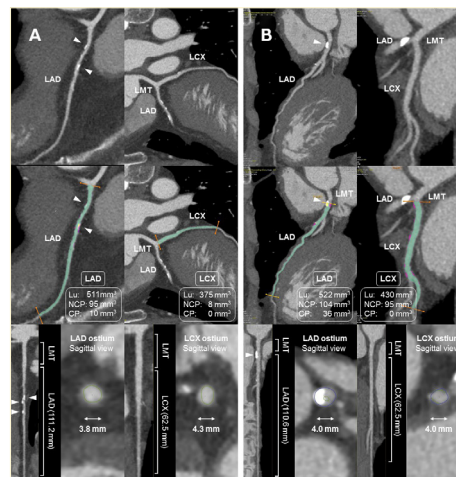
Computed tomography angiography (CTA): (A) Case 1; CTA showing no significant coronary artery stenosis in the left main trunk (LMT), left anterior descending (LAD), and left circumflex (LCX) (upper panel). Vessel components are indicated as following colors: green is lumen volume (Lu), red is non-calcified plaque volume (NCP), and yellow is calcified plaque volume (CP). The volume of Lu, NCP, and CP are 511 mm³, 95 mm³, and 10 mm³ for LAD and 375 mm³, 8 mm³, and 0 mm³ for LCX, respectively (middle panel). The vessel length coinciding with FFR_{CT} region of interest and ostium lumen diameter are 111.2 mm and 3.8 mm for LAD and 62.5 mm and 4.3 mm, respectively (lower panel). (B) Case 2; CTA showing no significant coronary artery stenosis in the LMT, LAD, and LCX (upper panel). The volume of Lu, NCP, and CP are 522 mm³, 104 mm³, and 36 mm³ for LAD and 430 mm³, 95 mm³, and 0 mm³ for LCX, respectively (middle panel). The vessel length coinciding with FFR_{CT} region of interest and ostium lumen diameter are 110.6 mm and 4.0 mm for LAD and 62.5 mm and 4.0 mm, respectively (lower panel). Arrowhead indicates CP.
